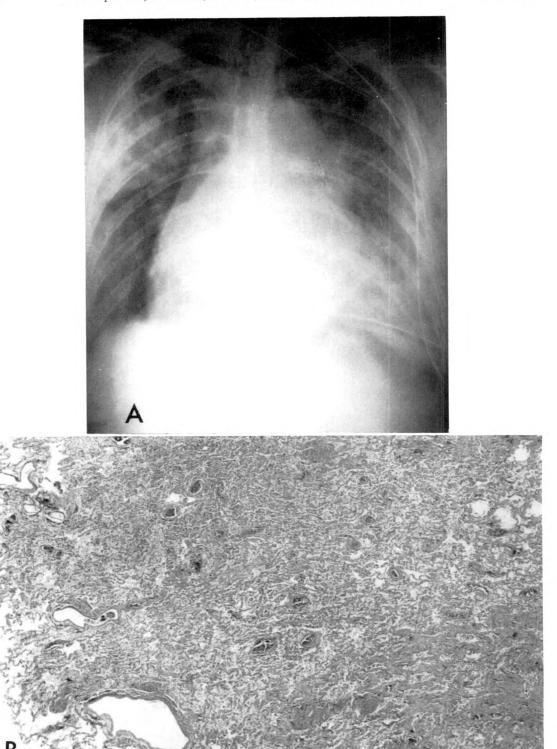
Patient who died 48 hours following replacement of the mitral valve. The perfusion was good. Total bypass time was 3 hours and 5 minutes and the main pulmonary artery was clamped. (A) Roentgenogram taken 12 hours after operation demonstrates bilateral coalescent homogeneous infiltrates. (B) Photograph of lung section showing diffuse red blood cell infiltration throughout the lung parenchyma.
